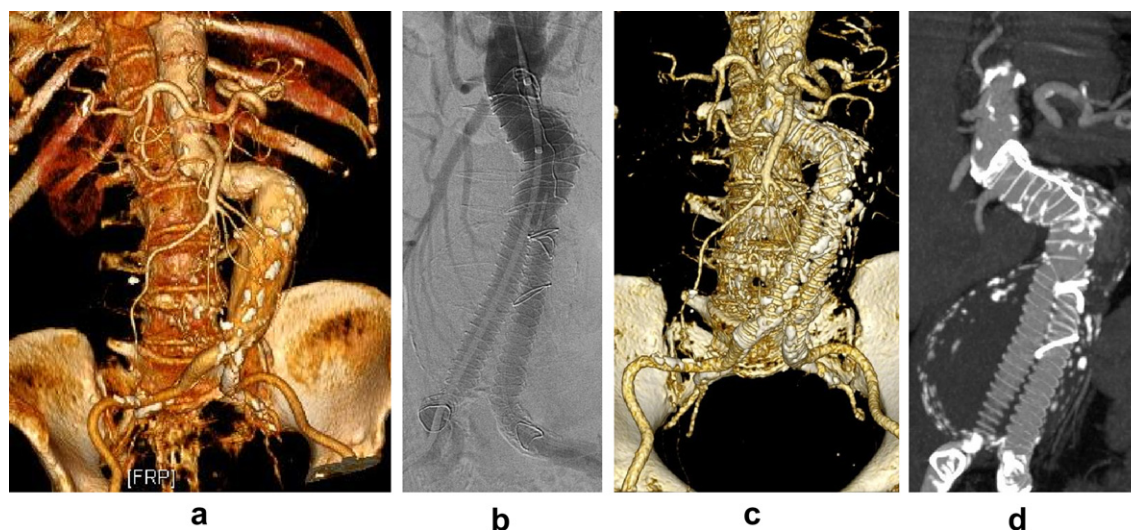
Aorfix stent graft in a patient with highly angulated anatomy; pre-operative CT (a) shows an infra-renal abdominal aortic aneurysm with neck angulation of just under 90°; intra-operative DSA (b) demonstrates the positioning of the graft and post-operative CT (c) and (d) demonstrate the conformity of the graft to the patient's anatomy.
